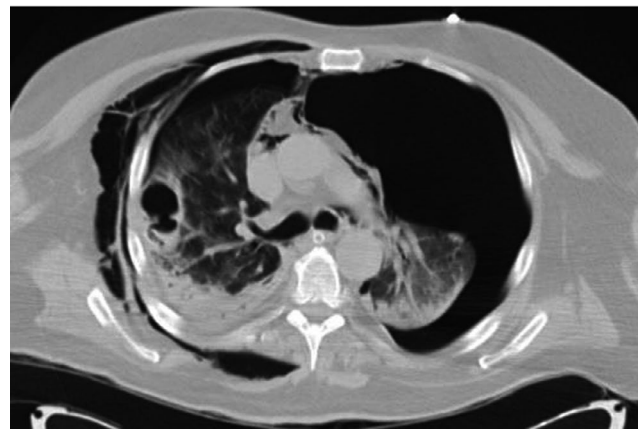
Chest multi-slice computed tomography (MSCT) 6 d after administration of tocilizumab. Chest MSCT showed a bilateral pneumothorax and subcutaneous emphysema of the thoracic wall—complications unrelated to the use of tocilizumab, as well as previously described ground-glass opacities and pulmonary consolidation. Comparing the previous MSCT finding, the effect of tocilizumab on the parenchymal recovery of the lungs could not be assessed because of the collapsed lung affected by the pneumothorax
